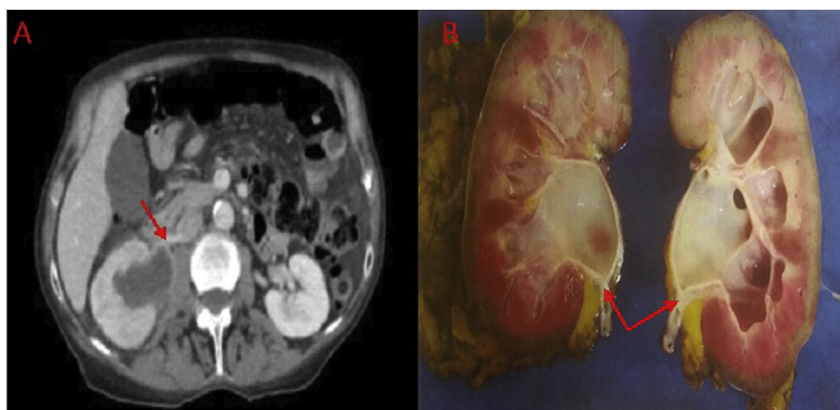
A) CT imaging showing enhancing pelvic-ureteric stricture (red arrow) and corresponding hydronephrosis. B) Macroscopic image of right kidney showing hydronephrosis with neoplastic stricture at pelvic-ureteric junction (red arrows). (For interpretation of the references to colour in this figure legend, the reader is referred to the Web version of this article.)
